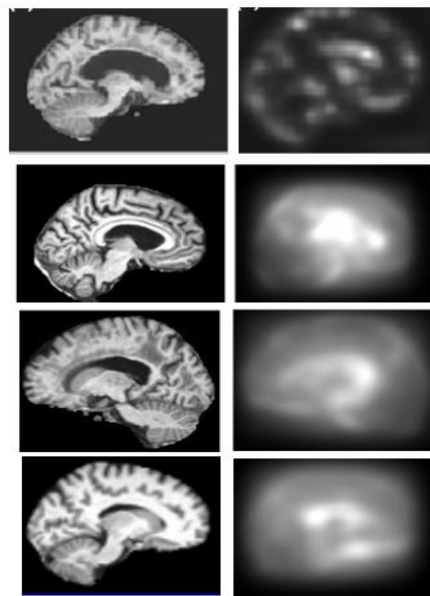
Saliency maps of Alzheimer's disease MRI images.
